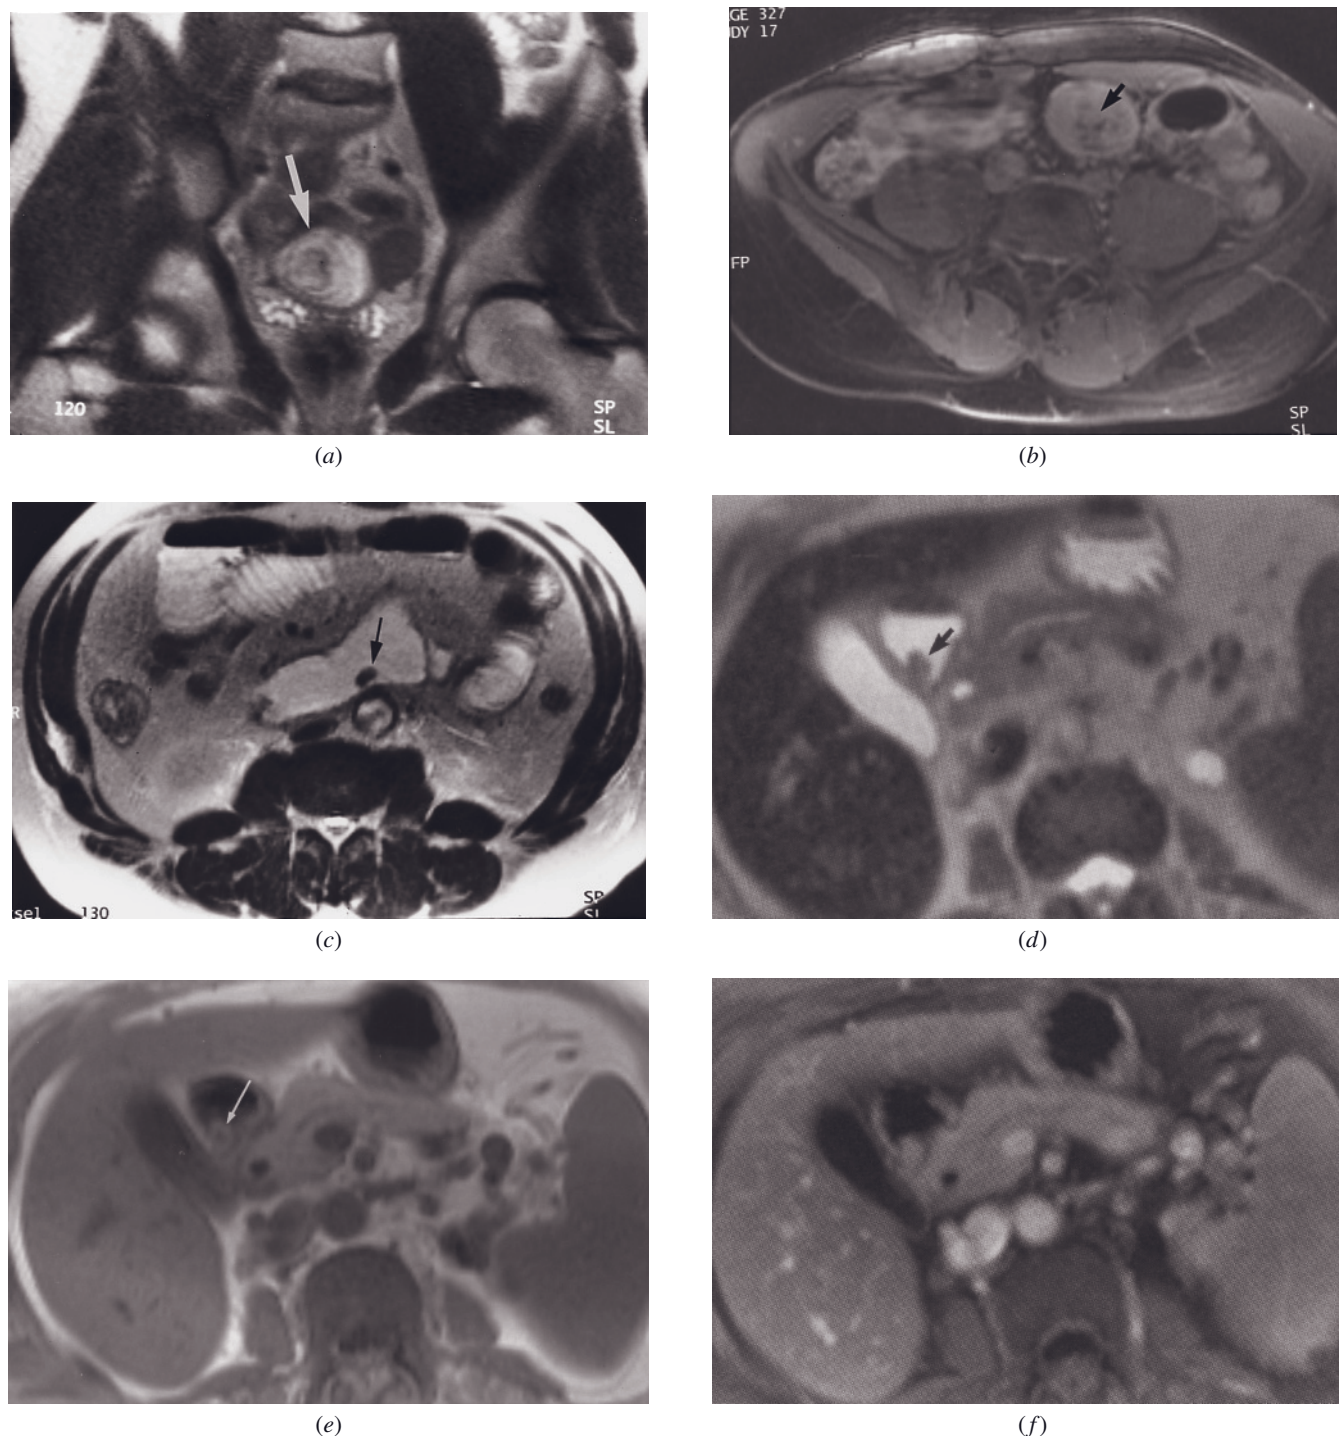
Small bowel polyps. T2-weighted SS-ETSE (a) and gadolinium-enhanced fat-suppressed SGE (b) images of a hamartoma in Peutz-Jeghers syndrome. A bowel-within-bowel appearance (arrow, a) is identified on the T2-weighted image (a) in the proximal jejunum because of intussusception. The intussusception is caused by a hamartomatous polyp that has acted as a lead point. The hamartoma is shown as a 1-cm uniformly enhancing mass (arrow) on the gadolinium-enhanced fat-suppressed SGE image (b). T2-weighted image (c) in a second patient demonstrates a 1-cm polyp (arrow) within a slightly dilated loop of duodenum. T2-weighted SS-ETSE (d), SGE (e), and 90-s postgadolinium fat-suppressed SGE (f) images in a third patient. T2 image shows a low-signal-intensity mass (arrow, d) measuring 1.5 cm located in the descending portion of the duodenum. Note that the high signal intensity of intraluminal fluid within the duodenum clearly delineates the polyp, which appears moderately low in signal intensity. Comparing precontrast (e) and postgadolinium (f) images, enhancement of the polyp is demonstrated, showing it to remain comparable in signal to the duodenal wall, reflecting the tissue nature of the polyp. (Reprinted with permission from Marcos HB, Semelka RC, Noone TC, Woosley JT, Lee JKT: MRI of normal and abnormal duodenum using half-Fourier single-shot RARE and gadolinium-enhanced spoiled gradient-echo sequences. *Magn Reson Imaging* 17: 869-880, 1999.)
